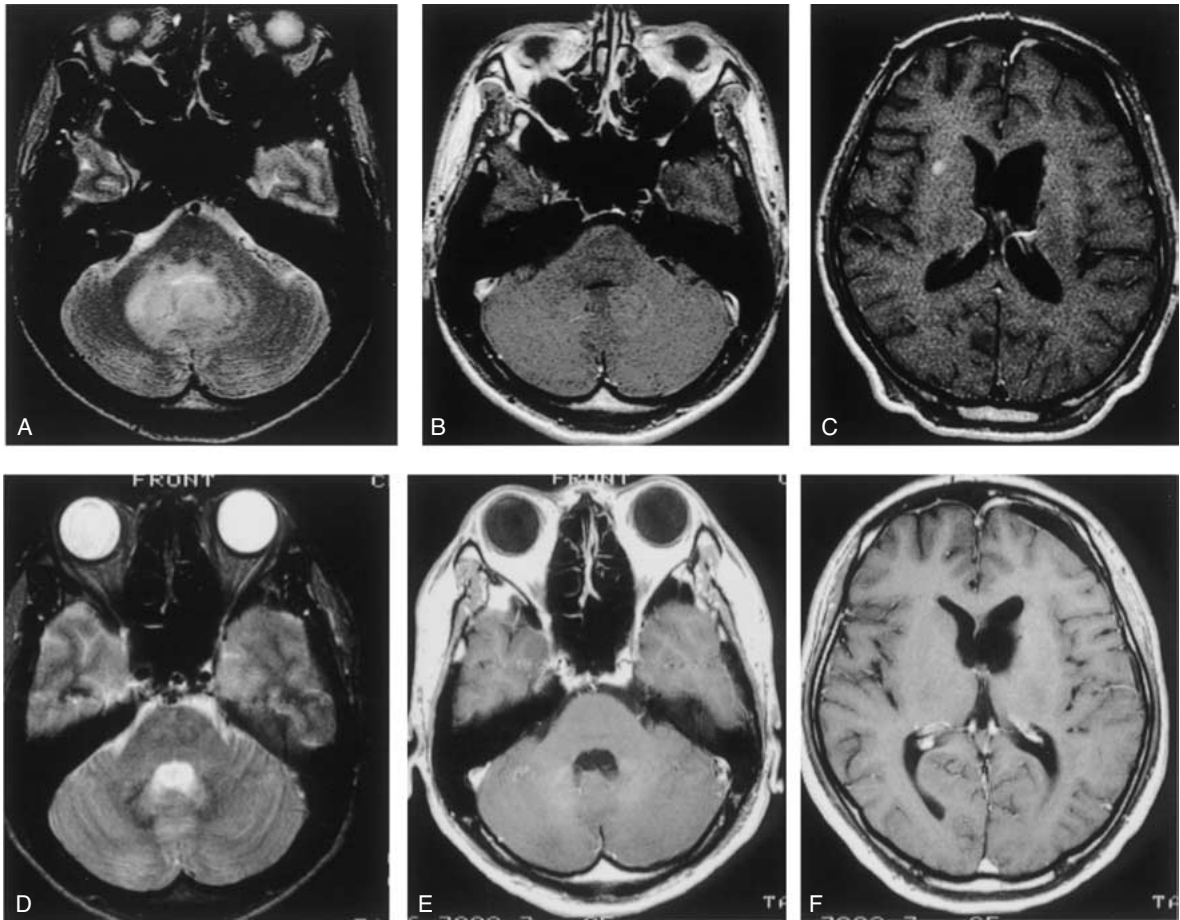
Case 2. T2-weighted (A, D) and T1-weighted MR images with Gd-DTPA (B, C, E, F). T2-weighted imaging showed a high intensity lesion around fourth ventricle 1 month after presentation with intractable vomiting (A–C). Complete disappearance of the high intensity lesion was obtained 6 months after gamma knife therapy (D–F).
